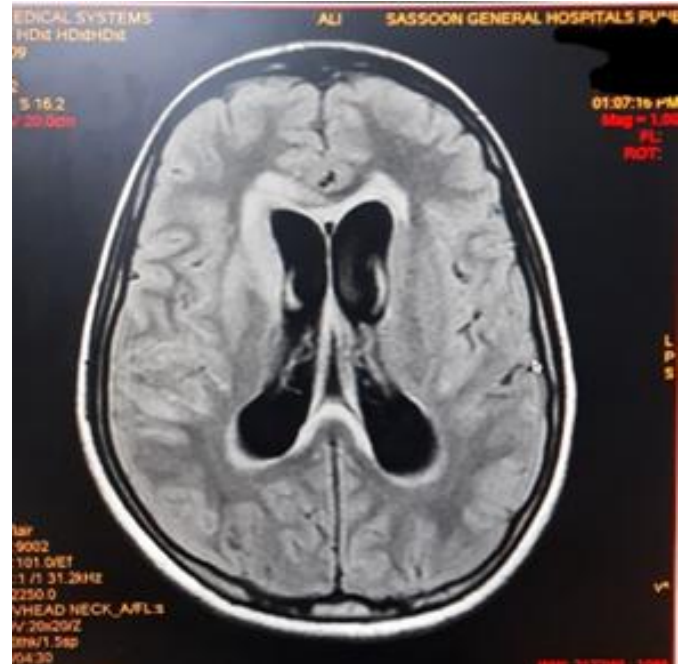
T2W FLAIR axial image showing hydrocephalus with periventricular ooze
